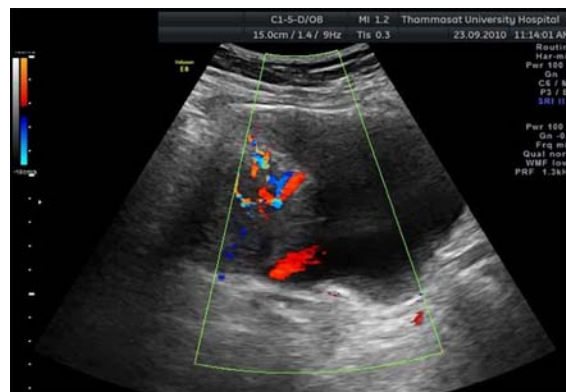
Colour Doppler flow noting placenta bulging into the bladder.
